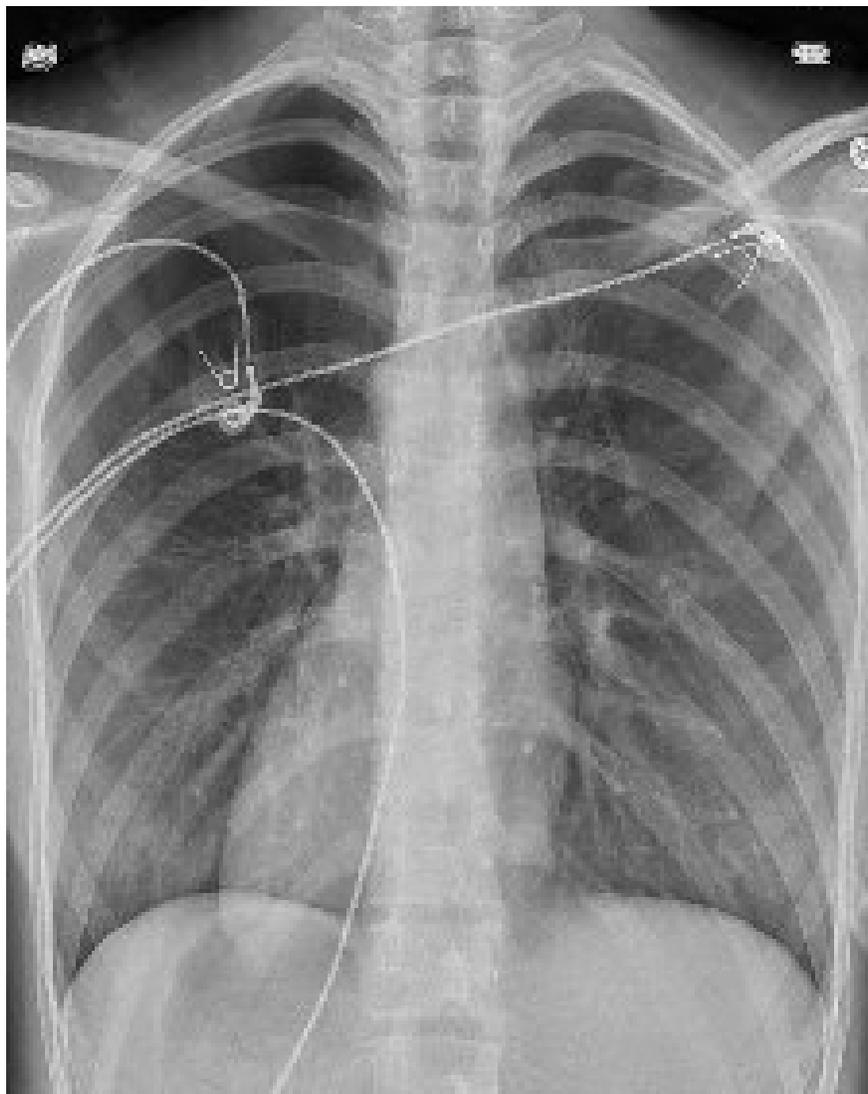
Chest radiograph showing small to moderate pneumothorax at admission
